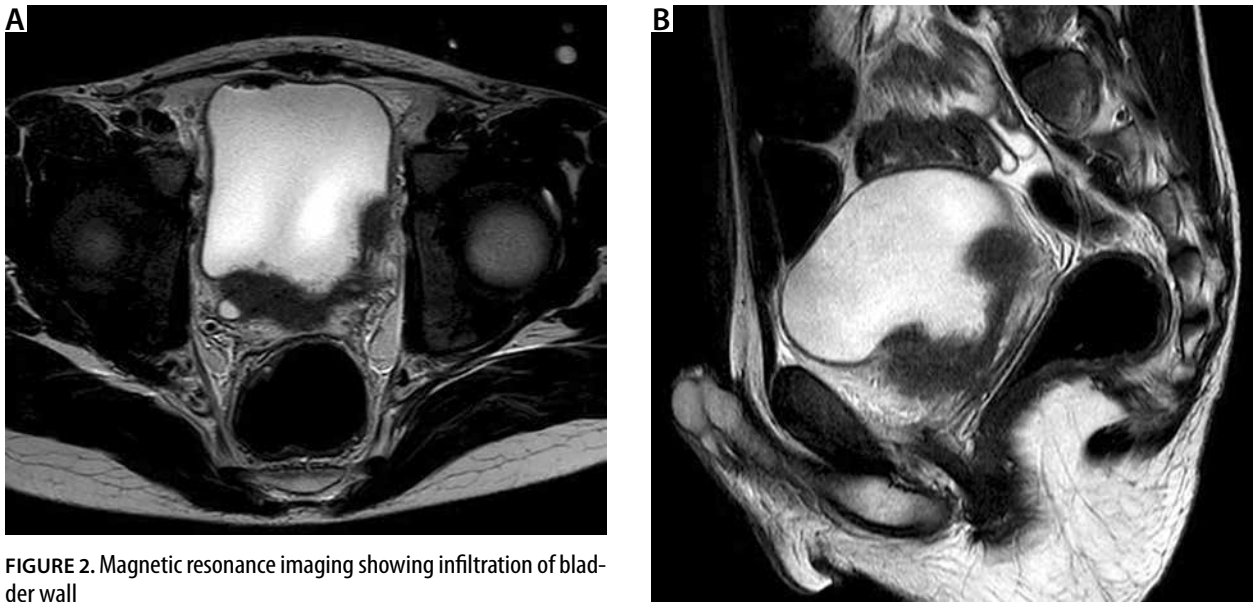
Magnetic resonance imaging showing infiltration of bladder wall
